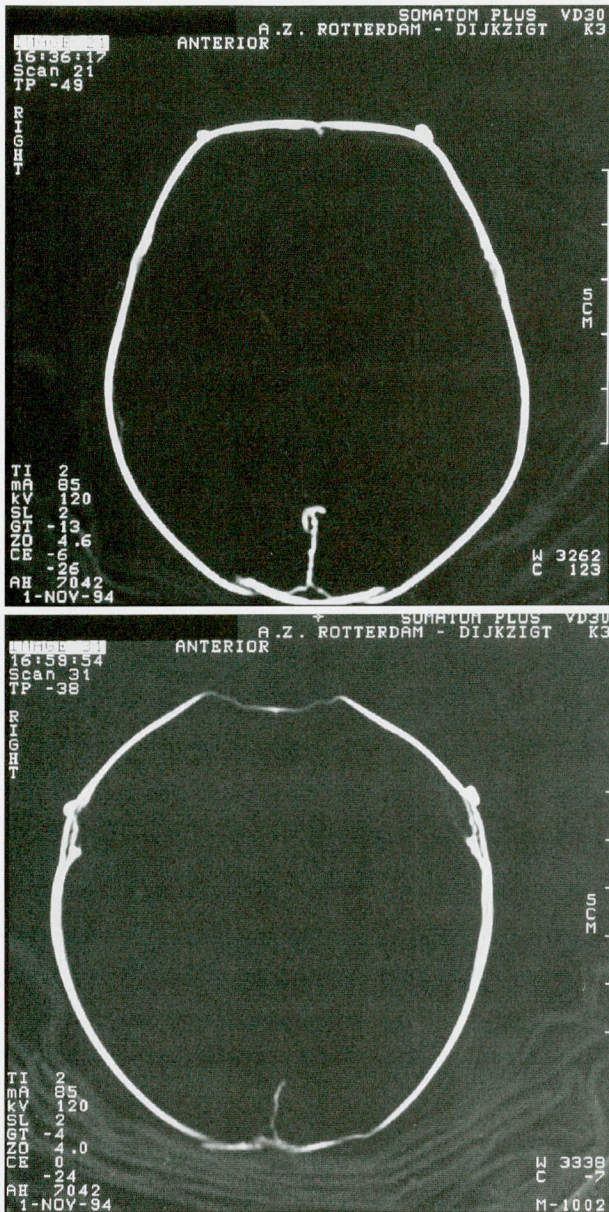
CT scans taken from a normal fetal dry skull (above) and an Apert dry skull (below) with the clay indicating the frontal tuber, i.e., bone center.
